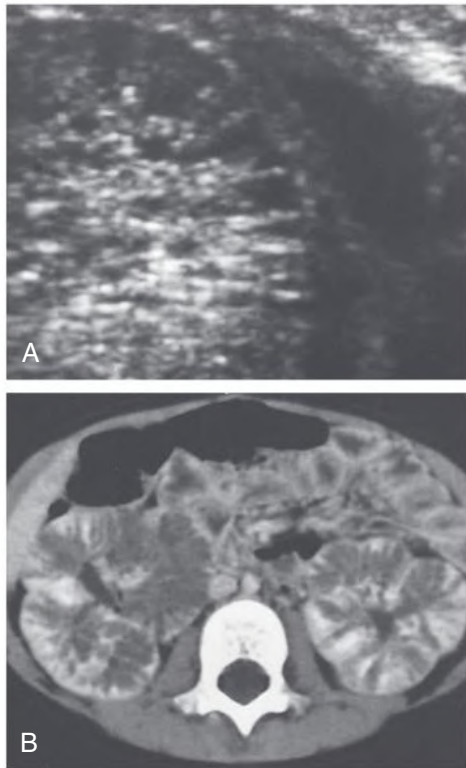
Radiologic Findings Associated With Autosomal Recessive Polycystic Kidney Disease. (A) Autosomal recessive polycystic kidney disease (ARPKD) in a neonate. High-resolution ultrasound reveals radially arrayed dilated collecting ducts. (B) ARPKD in a symptomatic 4-year-old girl. Contrast-enhanced computed tomography shows striated nephrogram and prolonged corticomedullary differentiation.
